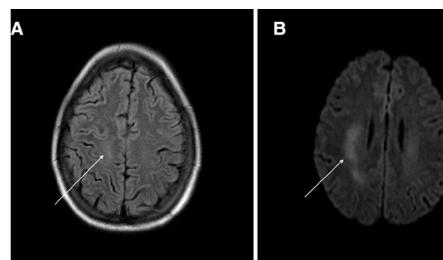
MRI brain images of case 7, one of the patients presenting with neurological events, which were not consistent with a single vascular territory stroke—two images (1) diffusion weighted (A) and (2) FLAIR images (B) subtle changes seen in the corona bilaterally. FLAIR, fluid-attenuated inversion recovery image.
